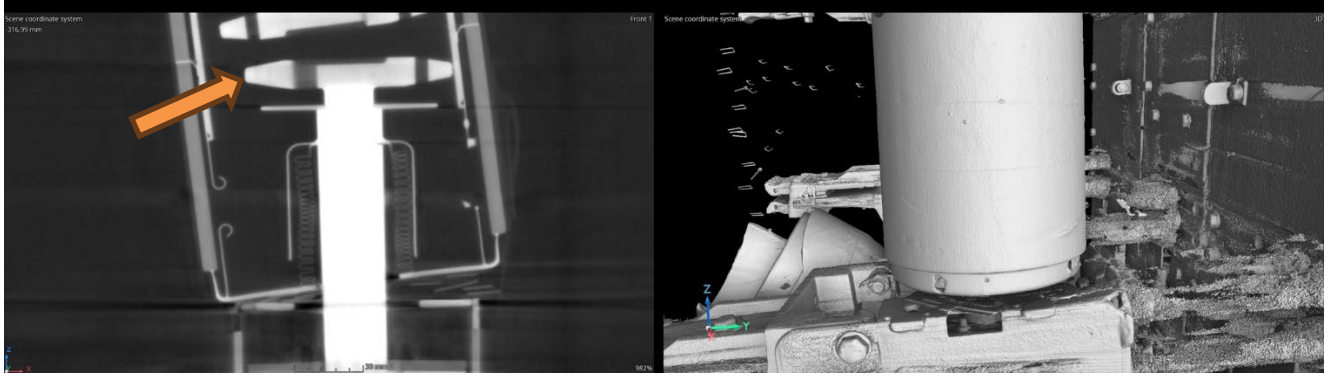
CT Scan imaging of the Incident Breaker No. 52's Vacuum bottle showing the condition of the breaker contacts (orange arrow).
